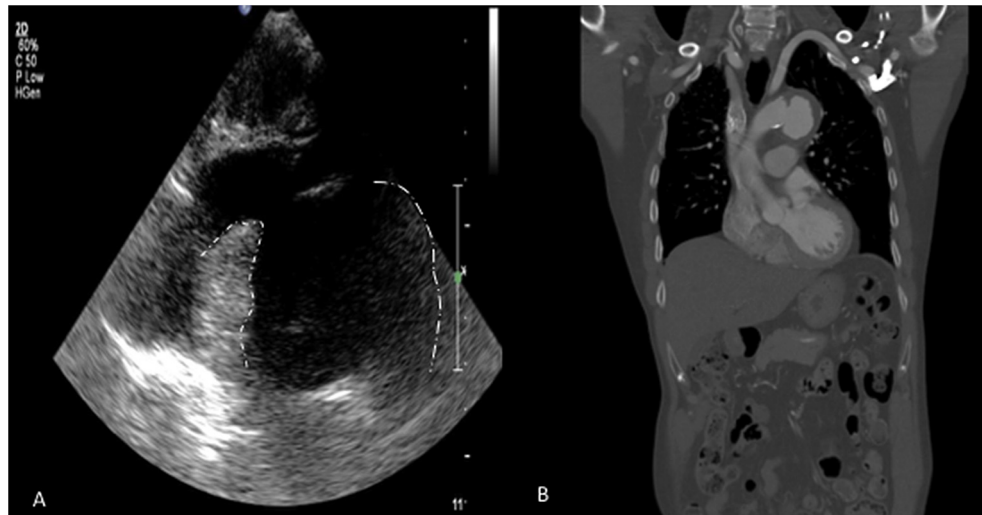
Saccular aneurysm of the descending aorta at the level of the isthmus. The aneurysm measured 4 cm on ultrasound (A) and 5.2 cm on CT scan (B). This discrepancy is probably due to the poor edge definition of the aortic isthmus on ultrasound due to the saccular nature of the aneurysm; however, ultrasound was discriminatory in identifying aneurysmal pathology at this level.
